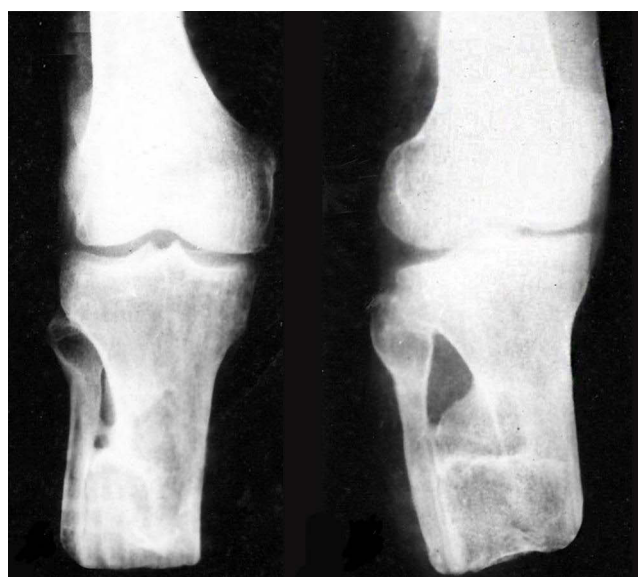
Radiographs of the residual limb 3 years after amputation (20.05.2023).
